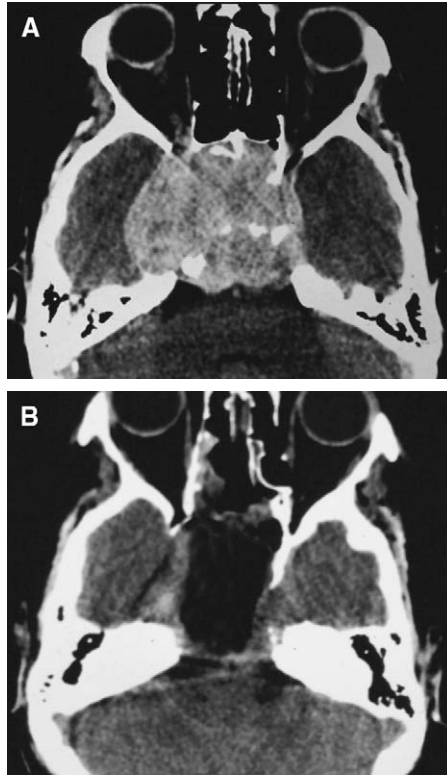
(A) Preoperative axial CT of a patient who has an extradural clivus chordoma. (B) Postoperative axial CT of the patient seen in Fig. 5A after endoscopic resection of the extradural clivus chordoma.
